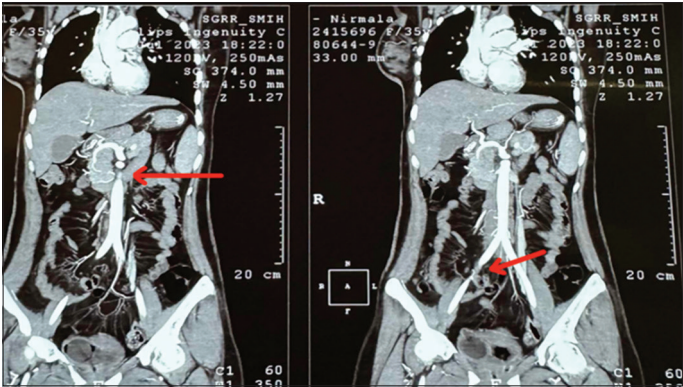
Computed tomography aortogram showing mural thickening and luminal narrowing involving the thoracic aorta and major branches (red arrows)
